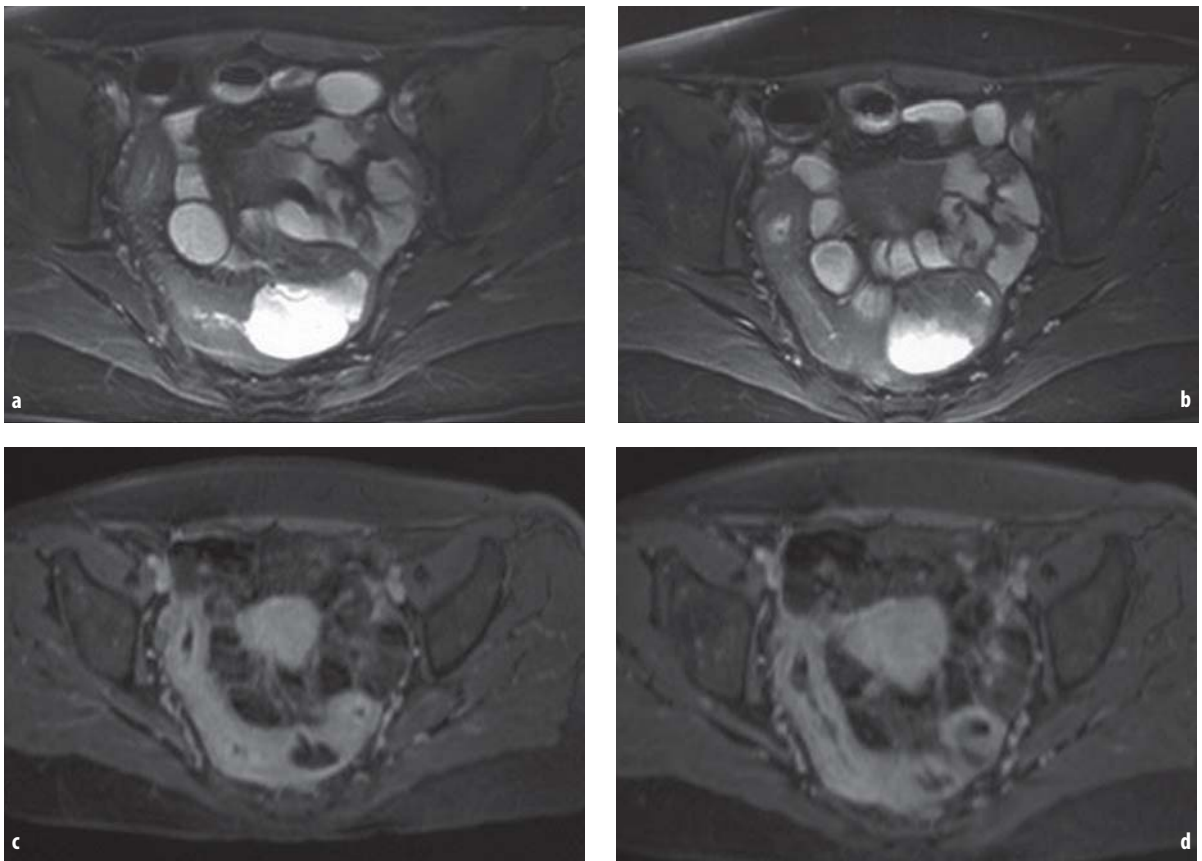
A 57-year-old female with active Crohn's disease. a, b Axial fat-suppressed true-FISP images show severe thickening of the terminal ileum with luminal stenosis and fibro-fatty proliferation. c, d After Gadolinium administration fat suppressed T1-weighted spoiled gradient echo images show enhancement of the bowel wall due to Crohn's disease activity
